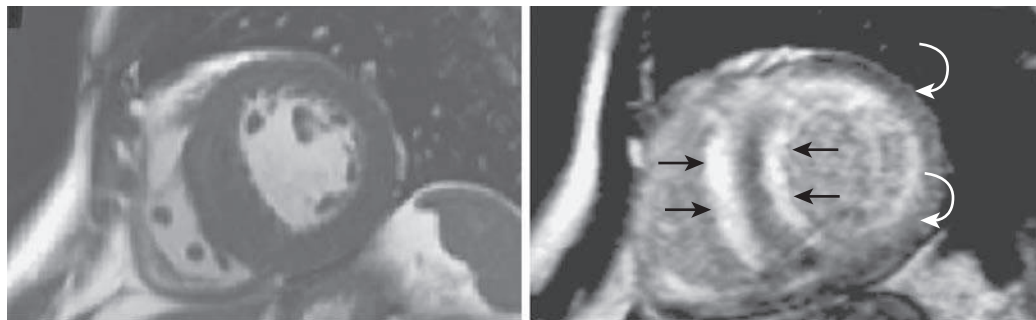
Cardiac amyloidosis. Cardiac magnetic resonance image with late gadolinium enhancement showing diffuse subendocardial enhancement in both left and right ventricles (straight arrows) with sparing of the epicardium and mid-wall (curved arrows). (From O’Hanlon R, Pennell DJ. Cardiovascular magnetic resonance in the evaluation of hypertrophic and infiltrative cardiomyopathies. *Heart Fail Clin.* 2009;5:369-387, with permission.)
